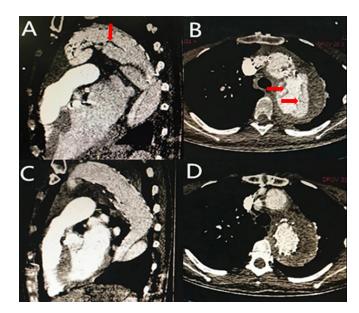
Preoperative and postoperative aortic CTA results. A and B, Preoperative CTA shows the false cavity (as indicated by the red arrows) caused by an endoleak. C and D, Postoperative aortic CTA indicates that the aortic arch has normal shapes, and the lumen of the descending aortic stent is unobstructed.
